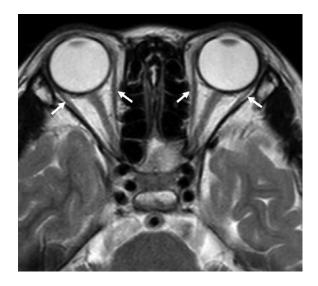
T2-weighted image (TR/TE 3652/90 msec, slice thickness/gap, 5/1 mm) shows atrophy of the bilateral medial and lateral rectus muscles (arrows).
